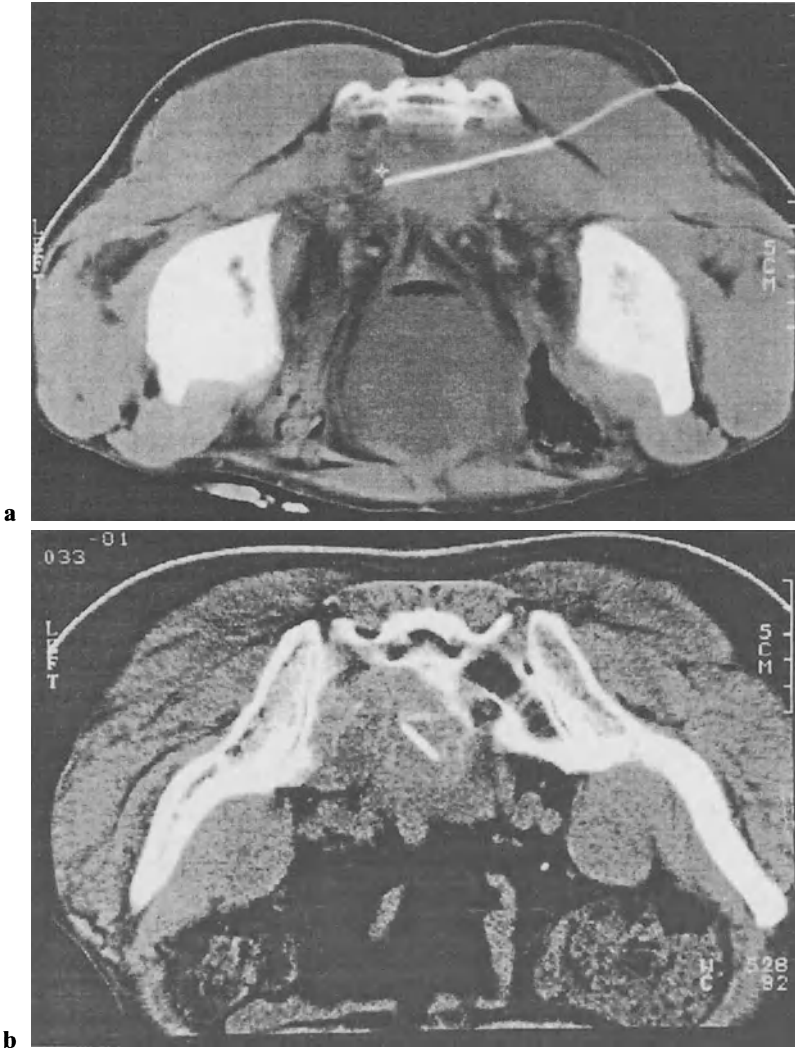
CT scans of transgluteally implanted thermometry catheters in a presacral recurrent rectal carcinoma. a Implantation in the transverse plane; implantation from caudal (with inclined gantry during CT guidance)
